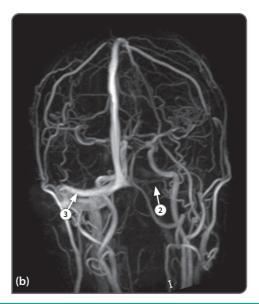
Venous thrombosis. (a) CT venogram, with arrow showing filling defect (dark hypodensity) in the left transverse sinus (empty delta sign) ① consistent with thrombosis in the left transverse sinus. (b) Magnetic resonance venogram showing absent flow in the left transverse and sigmoid sinuses, caused by occlusive thrombus ②, compared to the normally filling right transverse sinus ③.
